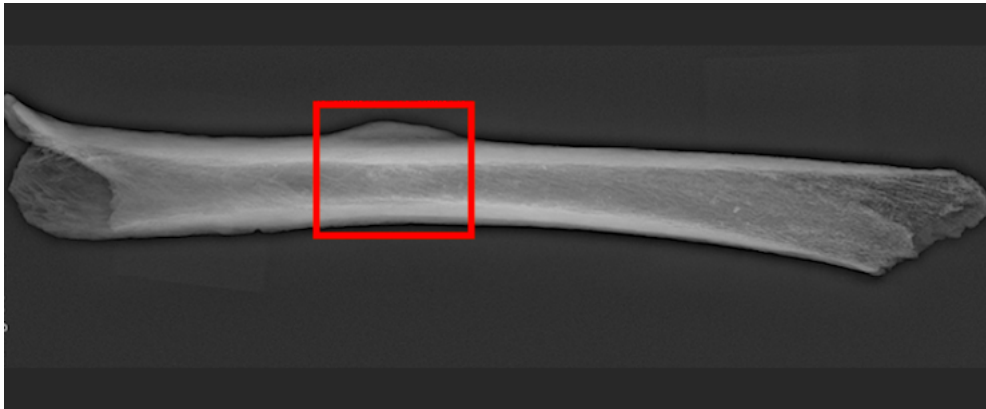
Nr.7, InvNr 27885, Grave 213: x-ray of the right femur with the affected area presented by a red squared. The compact bone was not affected (photographed by A.Wagner)
